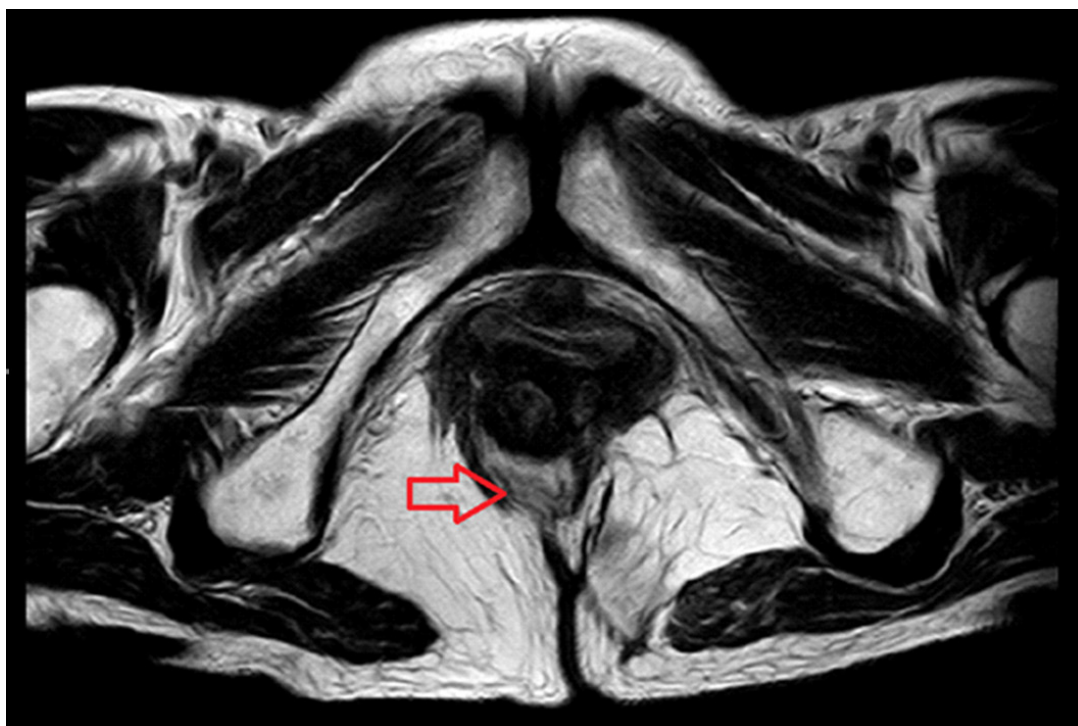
Progressive enlargement of the soft tissue lesion in the area of the tip of the fistulous canal on the T2-weighted MRI sequence.
